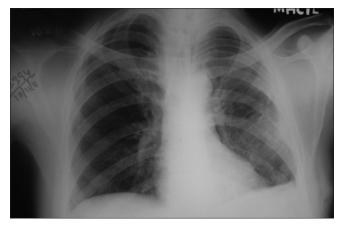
Chest radiograph showing near complete resolution of parenchymal opacities with left-sided pleural thickening
